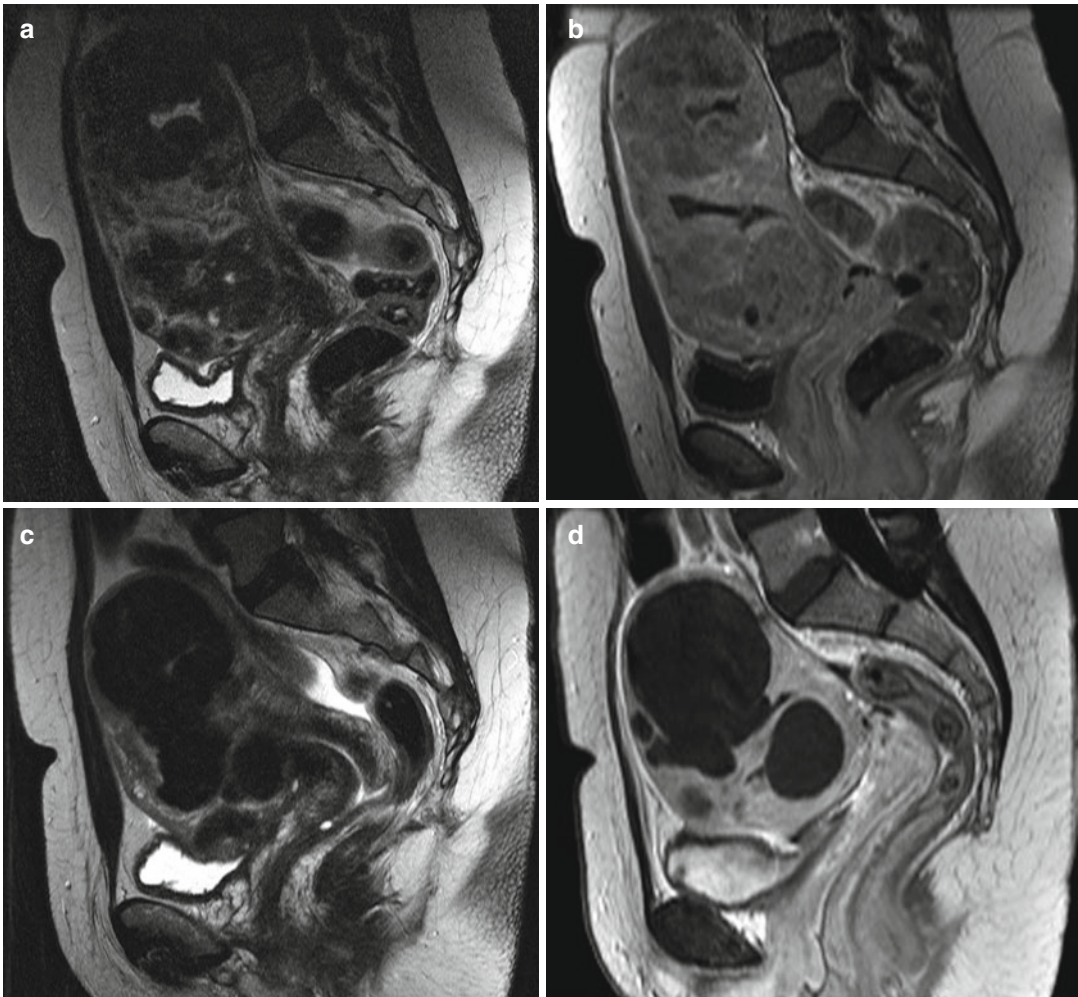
T2-weighted MRI of myoma, (a) before UAE without contrast; (b) after contrast, where there is enhancement in myoma (*light colors*); (c) T2-weighted image 6 months after embolization with marked reduced
